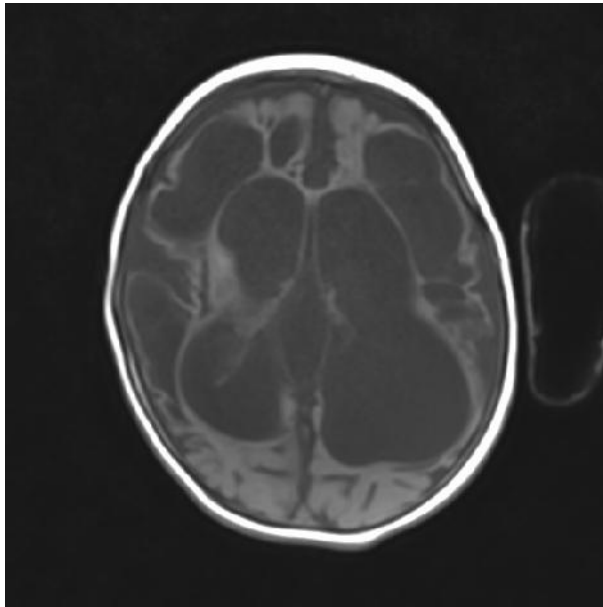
MRI IMAGES OF RIGHT ANTERIOR TEMPORAL ARACHNOID CYST
